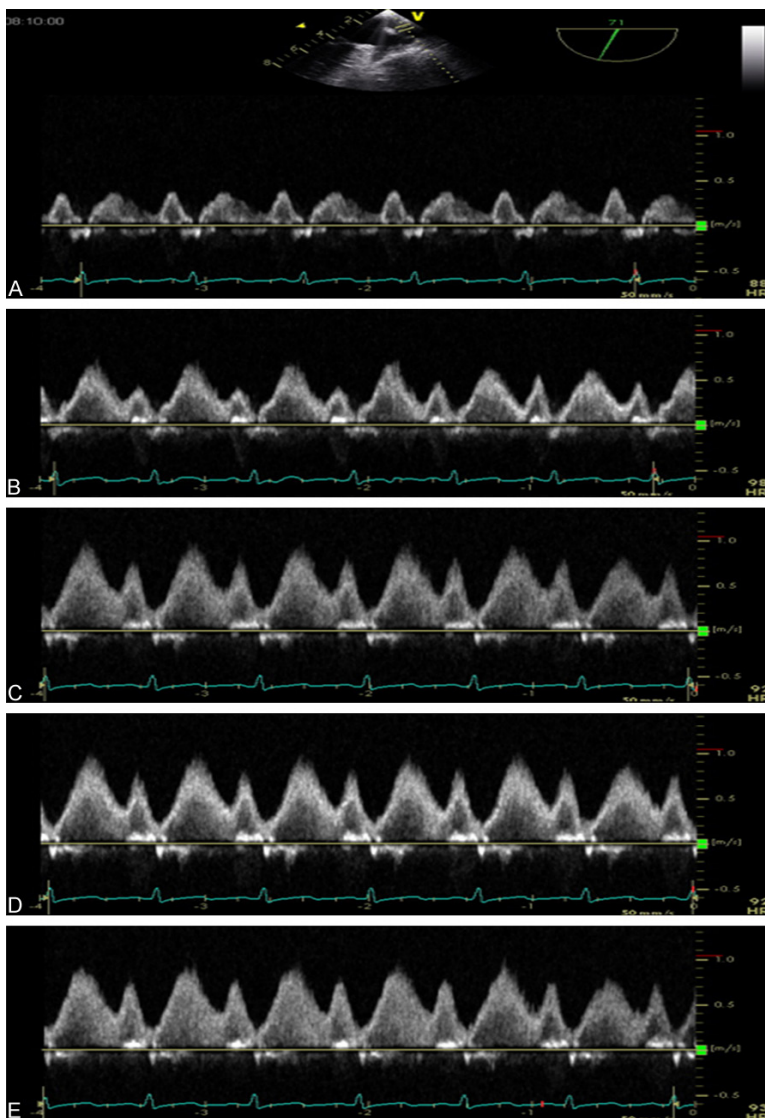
Pulsed-wave Doppler of left upper pulmonary venous blood flow velocity. A. 10 min after two lung ventilation in supine position. B. 10 min after two lung ventilation in lateral decubitus position. C. 10 min after one-lung ventilation in left lateral decubitus position. D. 20 min after one-lung ventilation in lateral decubitus position. E. 30 min after one-lung ventilation in left lateral decubitus position.
